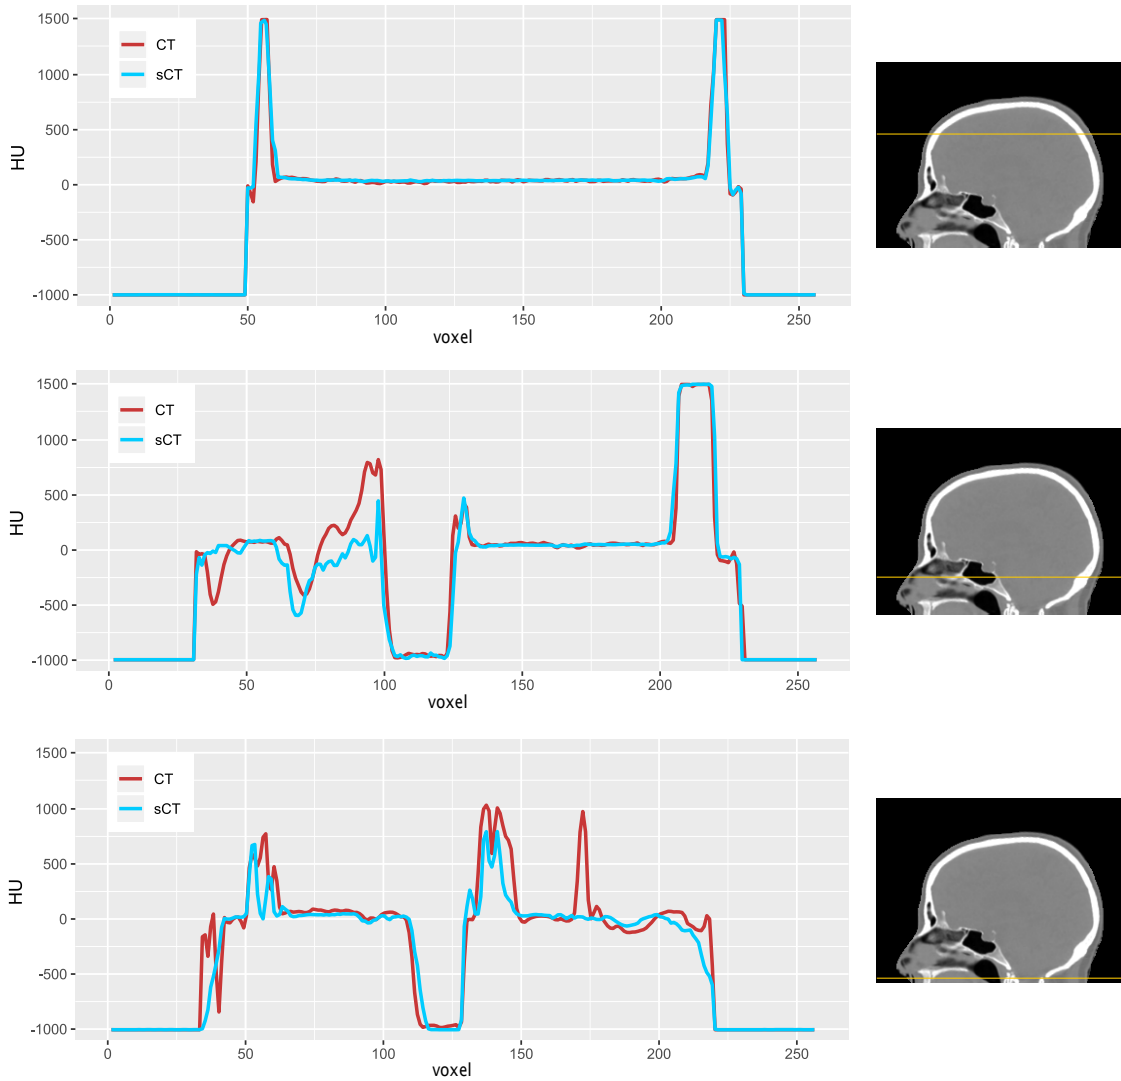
Profile plots of the HU values in real and synthetic CT at the mid-sagittal plane for three different axial planes, for a representative patient with  $MAE_{Body} = 70$  HU. The corresponding path lines are represented in yellow on the CT scan.
